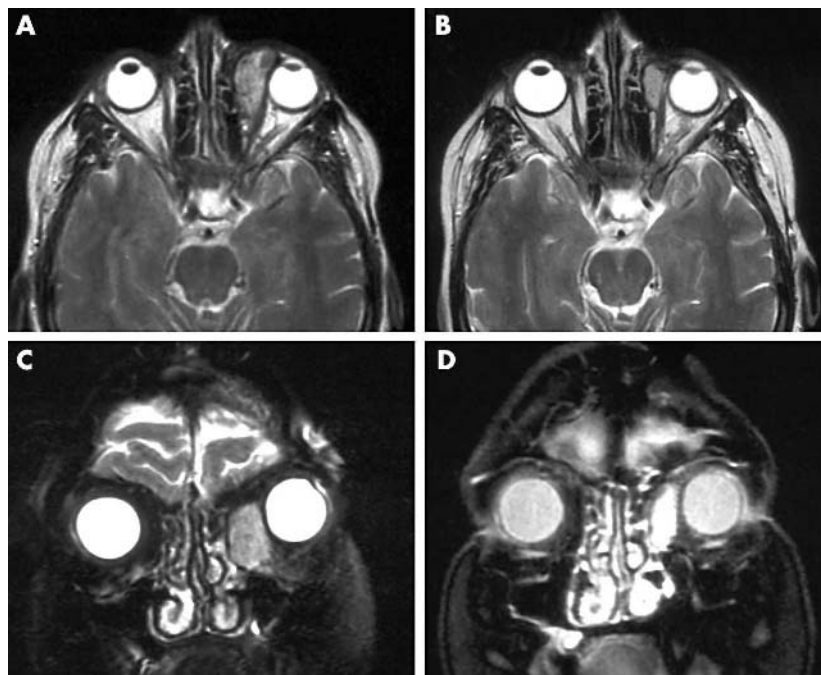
Axial (A) and coronal (C) MRI images before proton beam therapy. The haemangiopericytoma is evident in the left medial orbit. (B) and (D) show the same views 7 years after conservative surgery and proton beam therapy.
